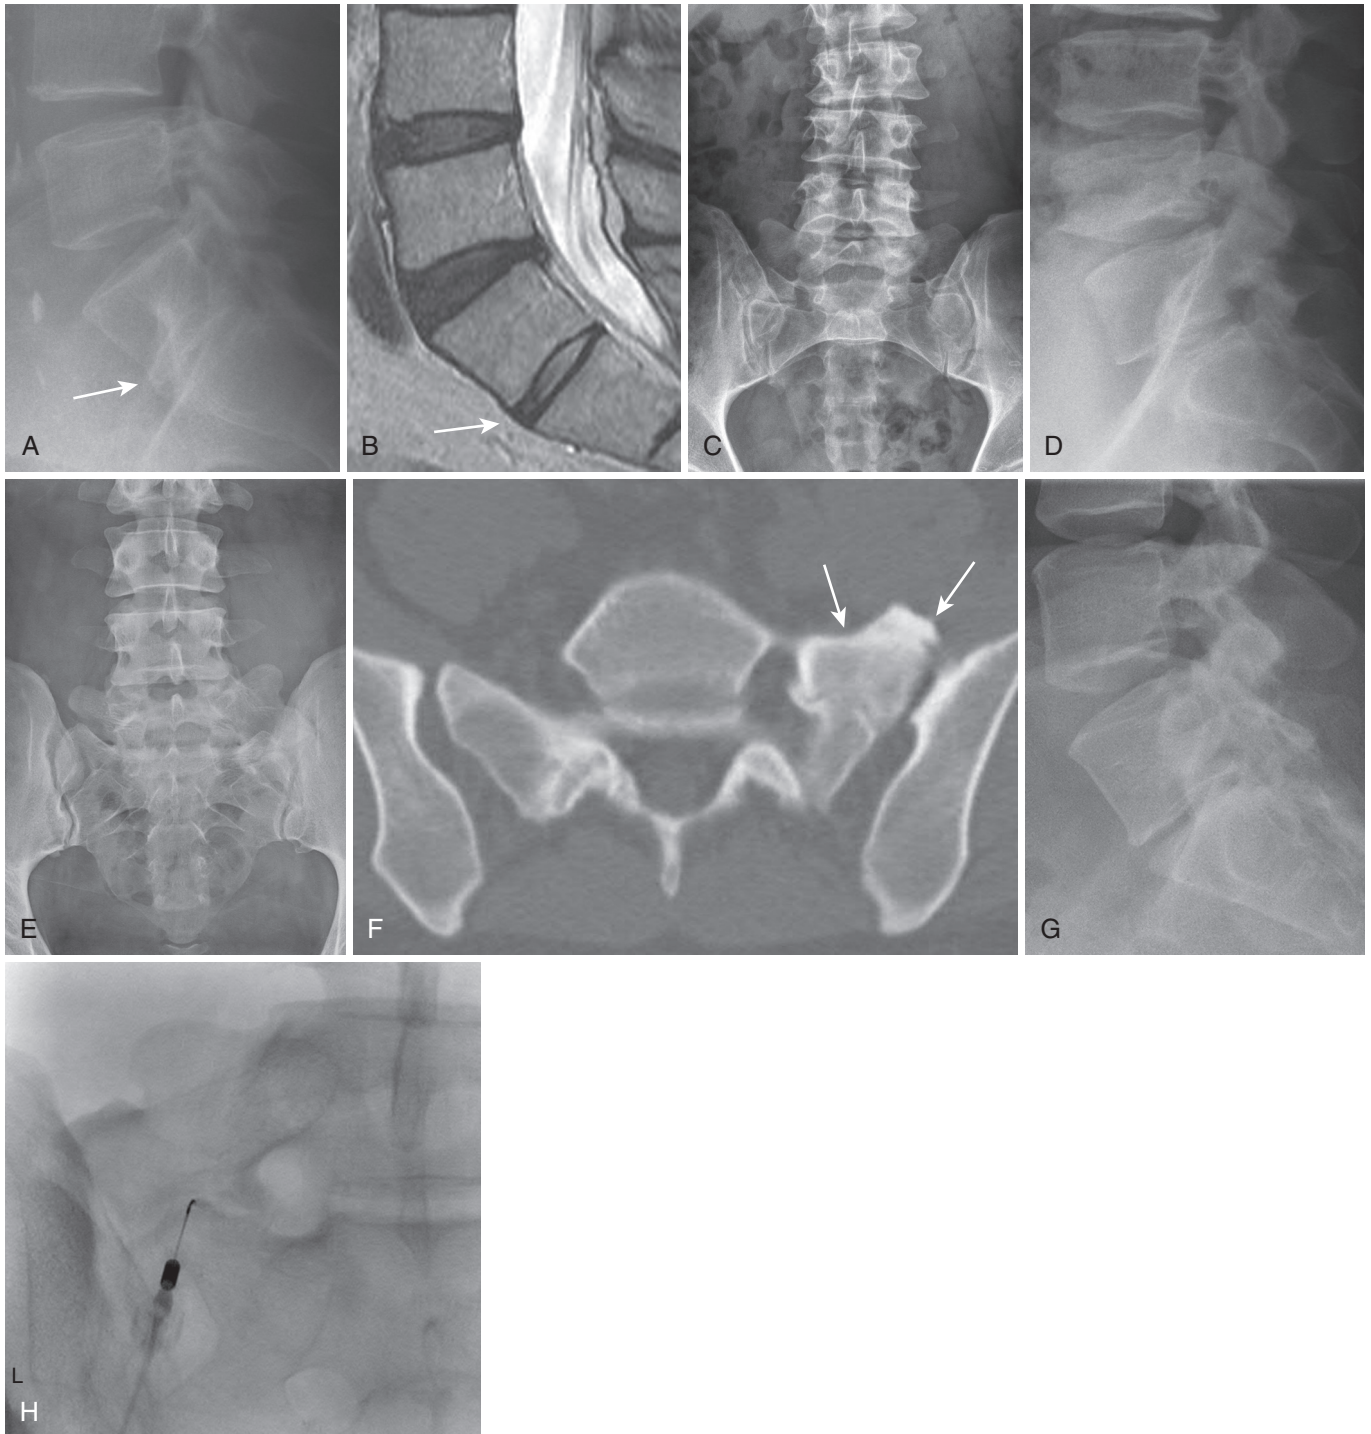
Transitional segments. Lateral radiograph (A) and sagittal T2 MRI image (B) demonstrate typical findings of a transitional segment interspace (*arrows*): a narrow disk space with parallel end plates and normal T2 signal intensity. Castellvi IIA transitional segment is demonstrated in frontal (C) and lateral (D) radiographs. Note right pseudoarthrosis. In another patient, frontal radiograph (E) shows a left-sided pseudoarthrosis, also seen on the axial CT image (*arrows* in [F]). Narrow, parallel end plates are visible in the transitional interspace on the lateral radiograph (G). This patient had axial pain attributed to the pseudoarthrosis; this was injected (H) with relief of the index pain.
